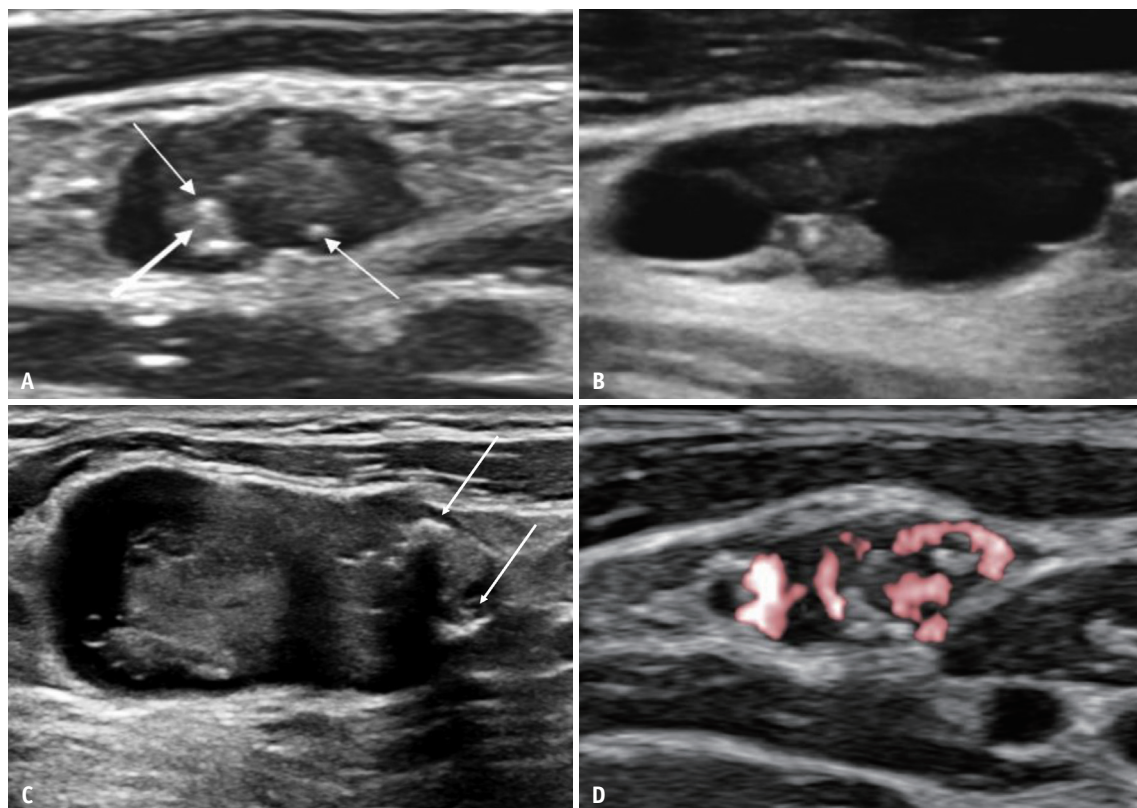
Ultrasonography features of suspicious lymph nodes.
